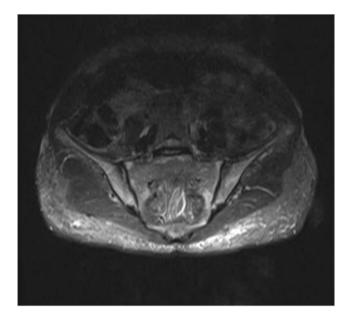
Sacroiliac magnetic resonance image: multiple hyperintense lesions (osteitis) in T2-weighted sequences in the bilateral sacroiliac joints.
